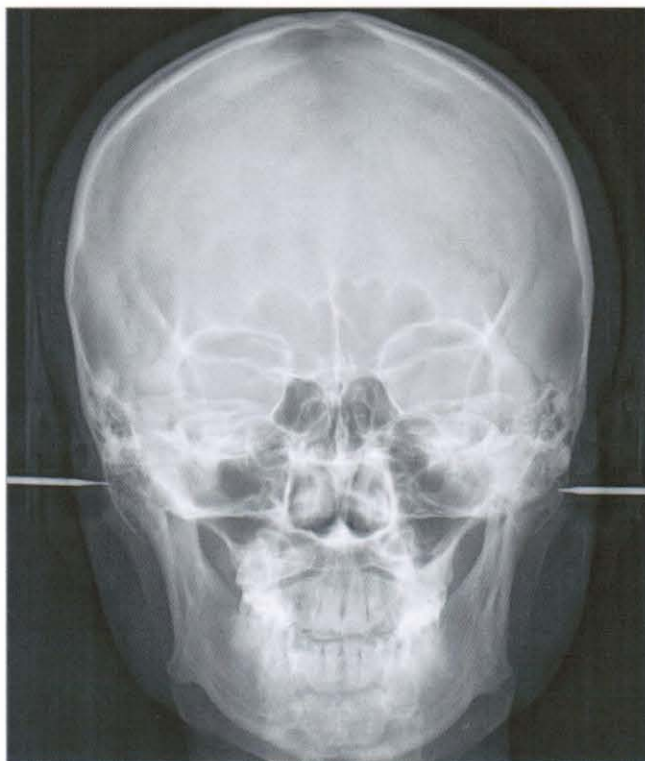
Post-treatment postero-anterior radiograph (2007, 3,22)
